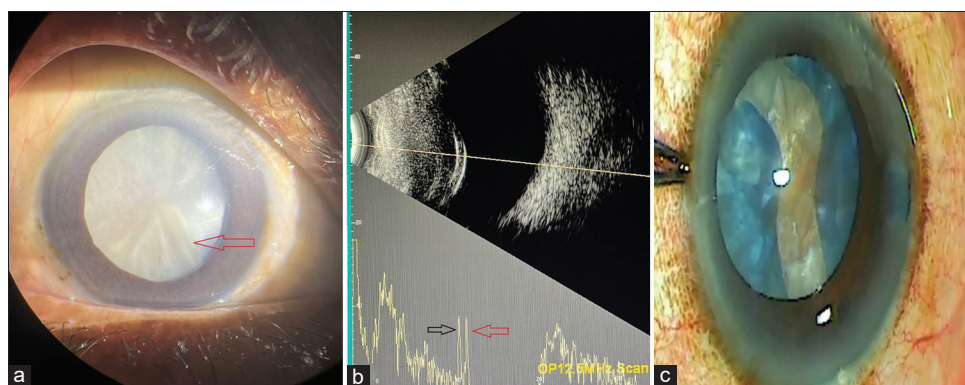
(a) Mature senile cataract with some fluid pockets in the anterior cortex (empty red arrow). (b) B-scan ultrasonography with A-scan overlay shows two full spikes compared to the retina and sclera: one corresponding to the posterior capsule of the lens (empty red arrow) and another representing the nucleus posterior margin. The hypoechoic area between the peaks corresponds to the liquefied cortex. (c) Classic Argentinian flag sign due to the radial extension of capsulorhexis from the central nick to both sides of the lens
